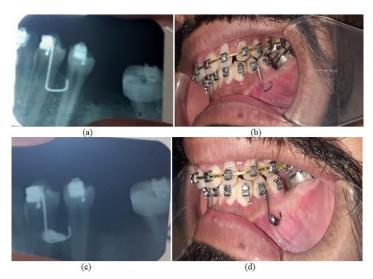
(a) Pre-operative intraoral periapical radiograph of a patient with L stent in place, (b) clinical photograph of the patient with L stent in place, (c) a 2x10 mm mini-implant is placed with the stent, (d) post operative IOPA of same patient after mini-implant placement
